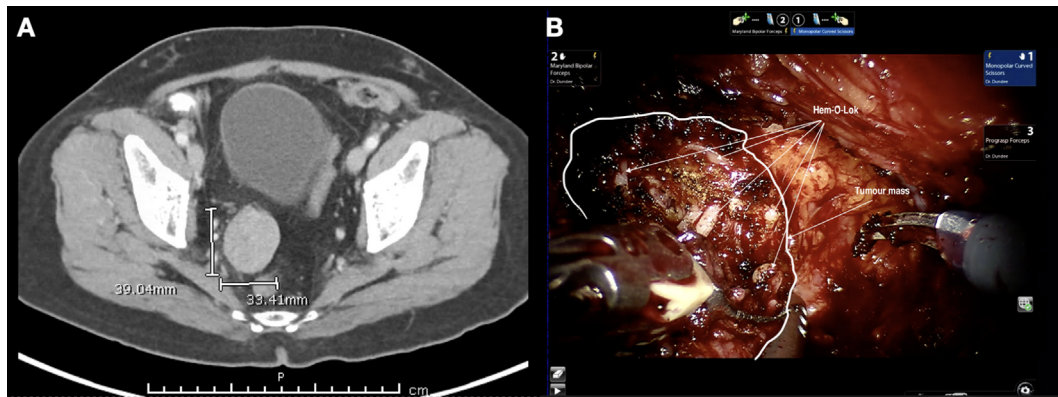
(A) Axial computed tomography imaging showing a large recurrence in the region of the right prostatic vascular pedicle. (B) Intraoperative imaging showing the base of the recurrence centred around multiple Hem-O-Lok clips.
